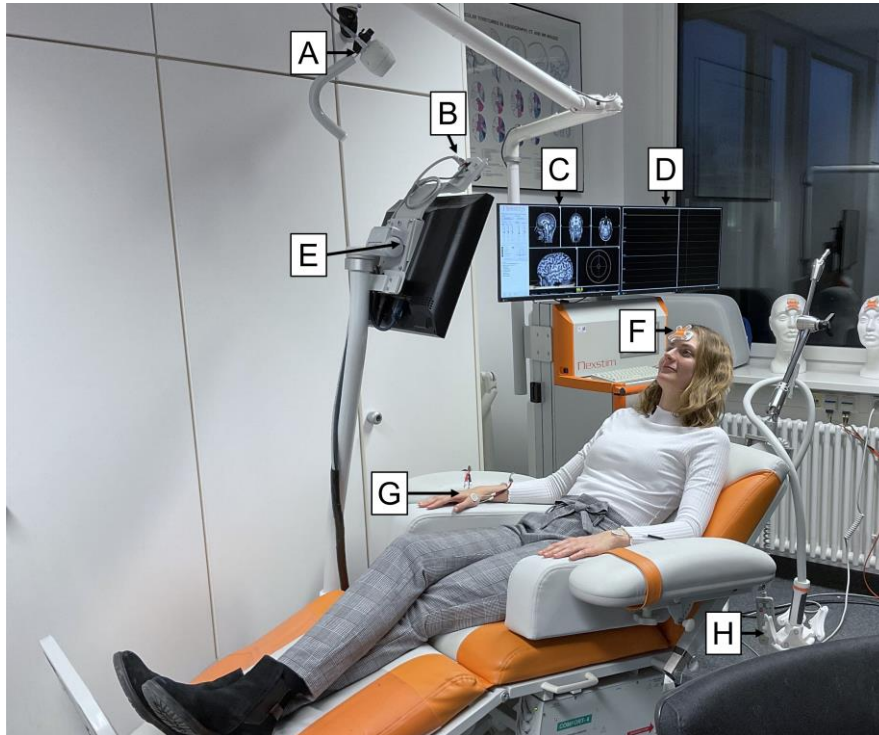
Setup of the nTMS system (Nexstim eXimia NBS system, version 5.1) for language mapping. Principal components comprise the stereotactic tracking device (A), the video camera for recording patient's language performance (B), two screens for displaying the 3D reconstruction of patients' MRI, neuronavigation, controlling settings, stimulation and task presentation as well as recording motor evoked potentials (C, D), a screen for displaying the pictures of the object naming task (E), head tracker for neuronavigation (F), surface electrodes to record motor evoked potentials (G), and the stimulation coil (H).
